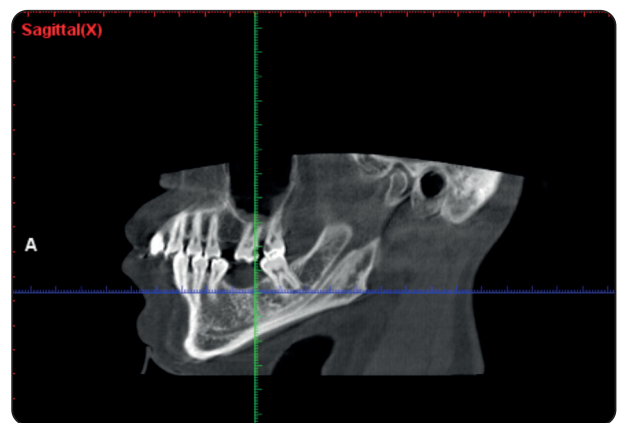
The sagittal view of the CBCT scan, the lines of orientation oriented so that their intersection lies just below the alveolar ridge in the center of the edentulous span of the missing molar. This was done in all the edentulous cases.
